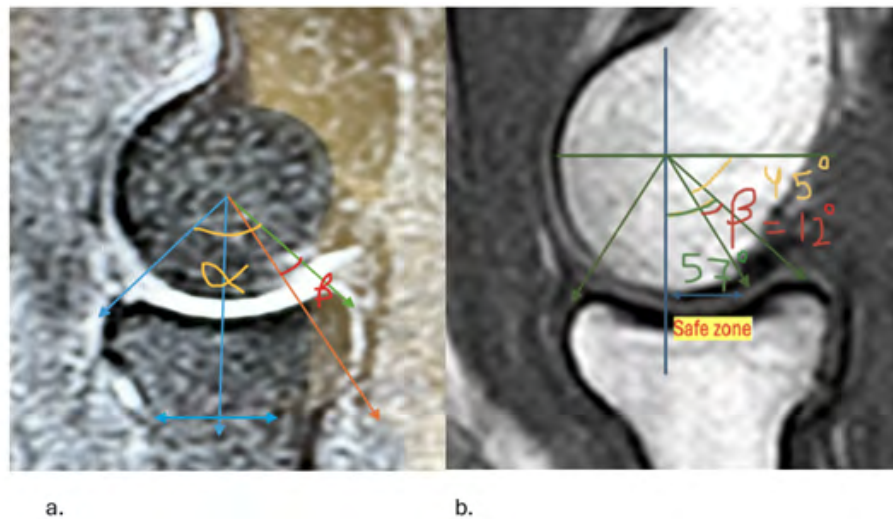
a. Sagittal MRI cut for the capitellum and the radial head in extension. The “ α ” angle represent 2 radians and the orange arrow cross at the critical point. b. Sagittal CT cut that demonstrate the safe zone wich equals roughly a quarter of the functional capitellar surface. “ γ ” angle is the angle between the blue arrow and orange arrow.
